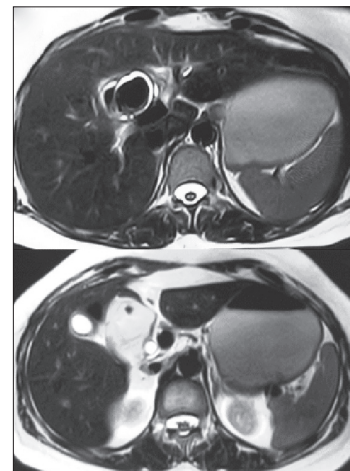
Magnetic resonance imaging abdomen
